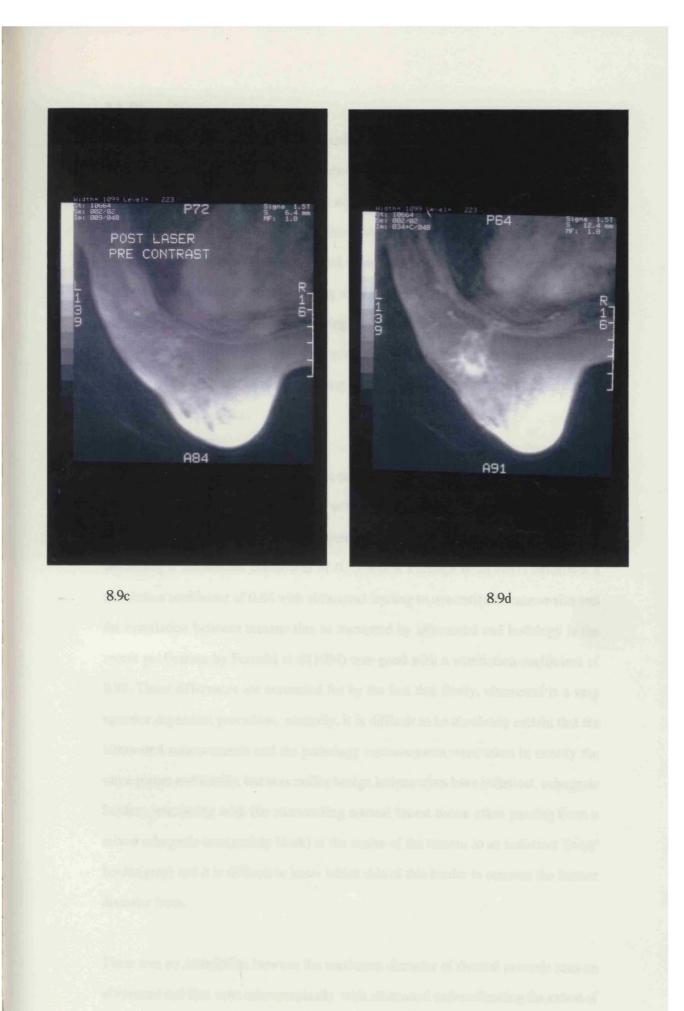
MRI scans a) pre laser pre-contrast b) pre-laser post contrast, the tumour enhances(arrowed) c) post laser pre-contrast and d) post laser post contrast
